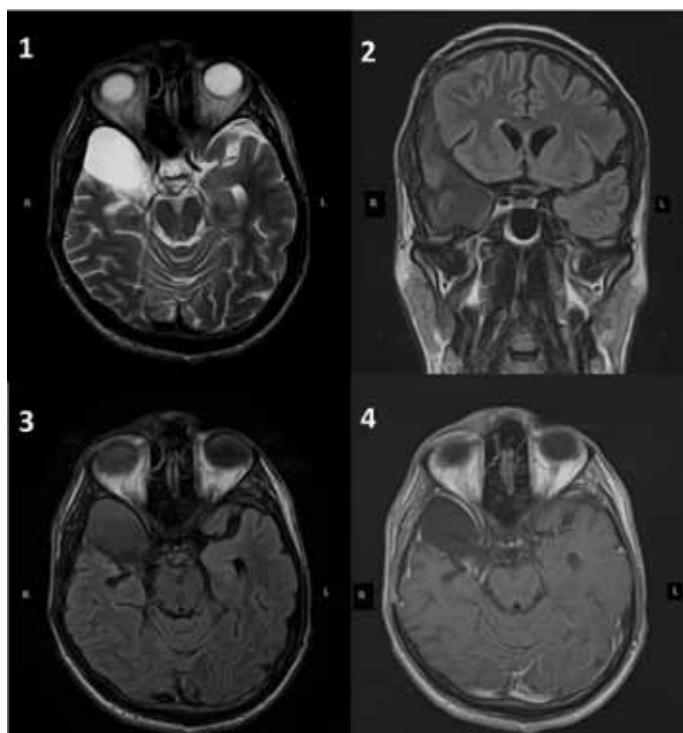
High Tesla MRI of the brain dated 07.09.2016. Presents the condition after the surgical procedure because of the tumor in medial parts of right temporal lobe. Signs of left masses are ab-sent. 1 – T2 axial; 2,3 – FLAIR coronal; 3 – FLAIR axial; 4 – T1c
